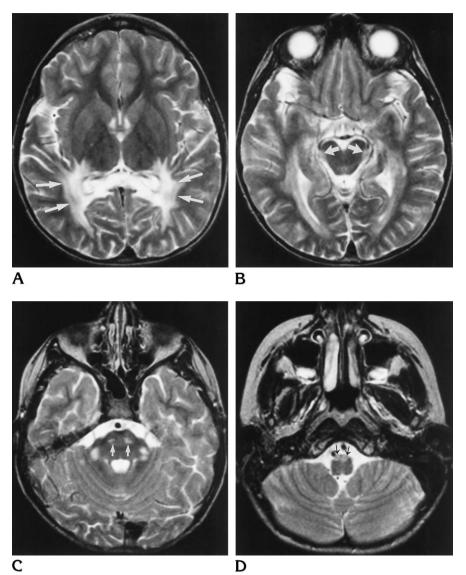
Axial spin-echo MR images (2500/80) in an 8-year-old boy with progressive decline in behavior.
